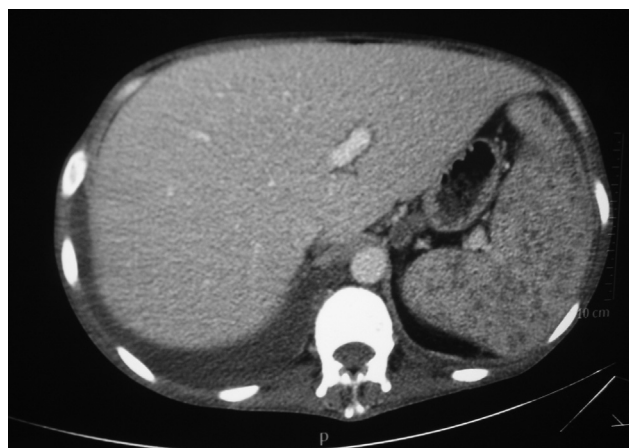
Hypodense nodular lesions in the liver and spleen, and mesenchymal multiple lymphadenopathy in the abdominal CT.
